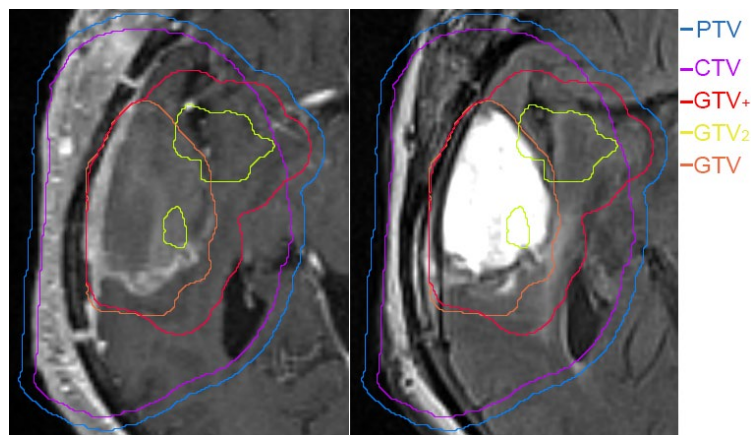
Example target volumes for dose boost on one axial slice, GTV₂ = metabolic abnormalities, GTV₊ = GTV+GTV₂+enlargement; left) MRI T1 post gadolinium injection; right) MRI FLAIR
